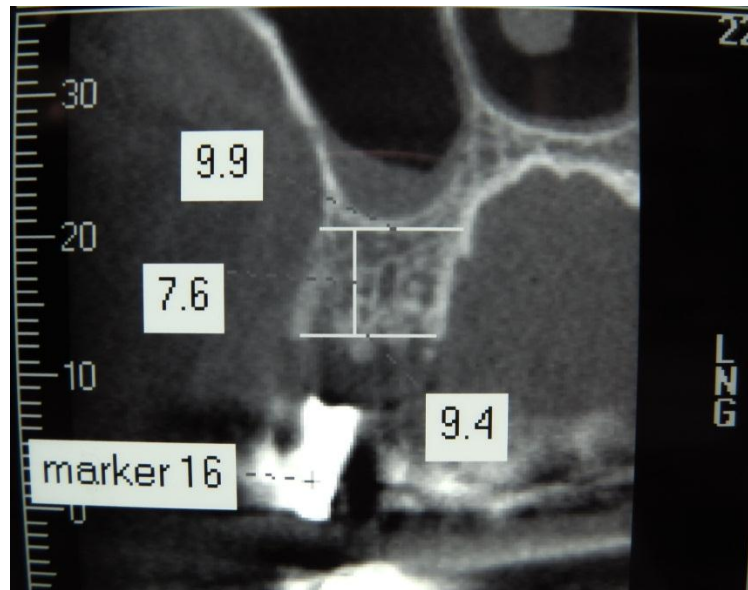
Accurate evaluation of bone volume at the surgical site using CBCT
